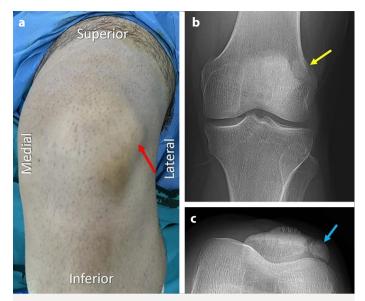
(a) Clinical appearance of the kneefrom the anterior aspect (red arrow shows the bony prominence caused by the bipartite patella fragment). (b) anteroposterior, and (c) tangential knee radiographs showing the bipartite patella (yellow and blue arrows).
